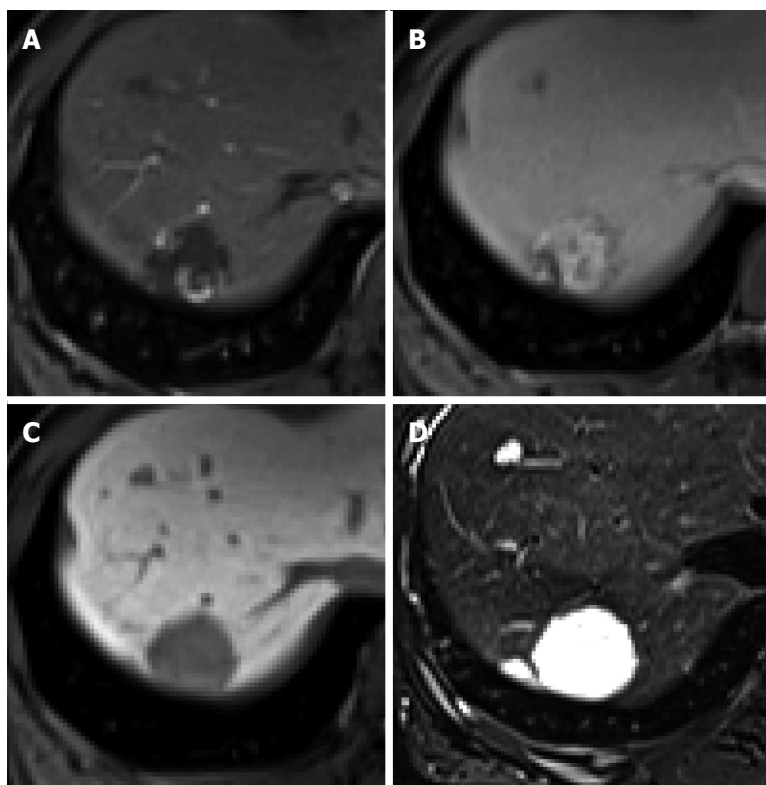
Hepatic hemangioma in a 45-year-old woman. A: Hepatic arterial phase using gadoxetic acid shows peripheral nodular enhancement of the tumor in segment 7; B: Transitional phase shows centripetal and prolonged enhancement; C: Hepatobiliary phase shows hypointense defect relative to hepatic parenchyma; D: T2-weighted image shows bright and high signal intensity.
